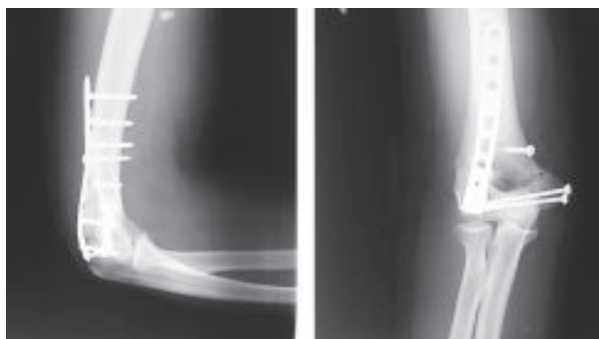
Post- operative x-ray of elbow (at 2 weeks)
